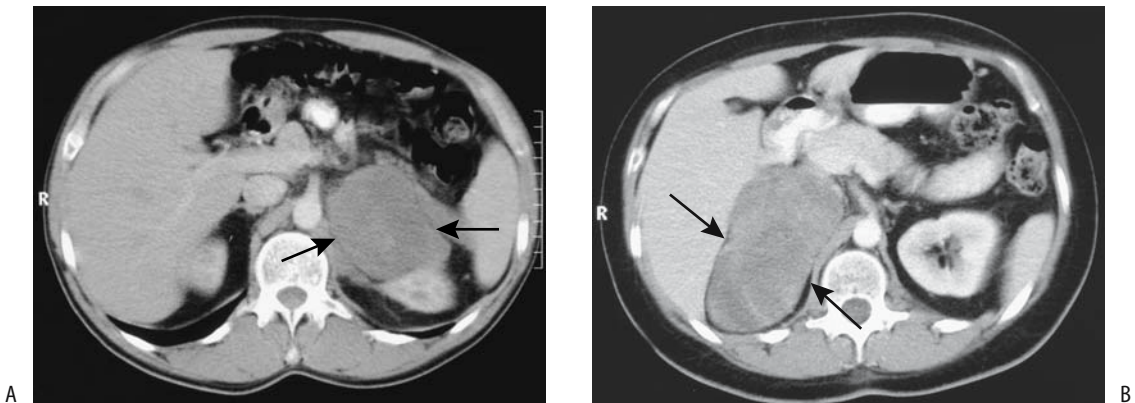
A: Left adrenal pheochromocytoma. Computed tomography reveals a large, homogeneous, poorly enhancing tumor (arrows) displacing the left kidney. B: Right adrenal pheochromocytoma. Computed tomography identifies a large, homogeneous, poorly enhancing tumor (arrows). (Courtesy of Algidas Basevicius, M.D., Kaunas Medical University, Kaunas, Lithuania.)
